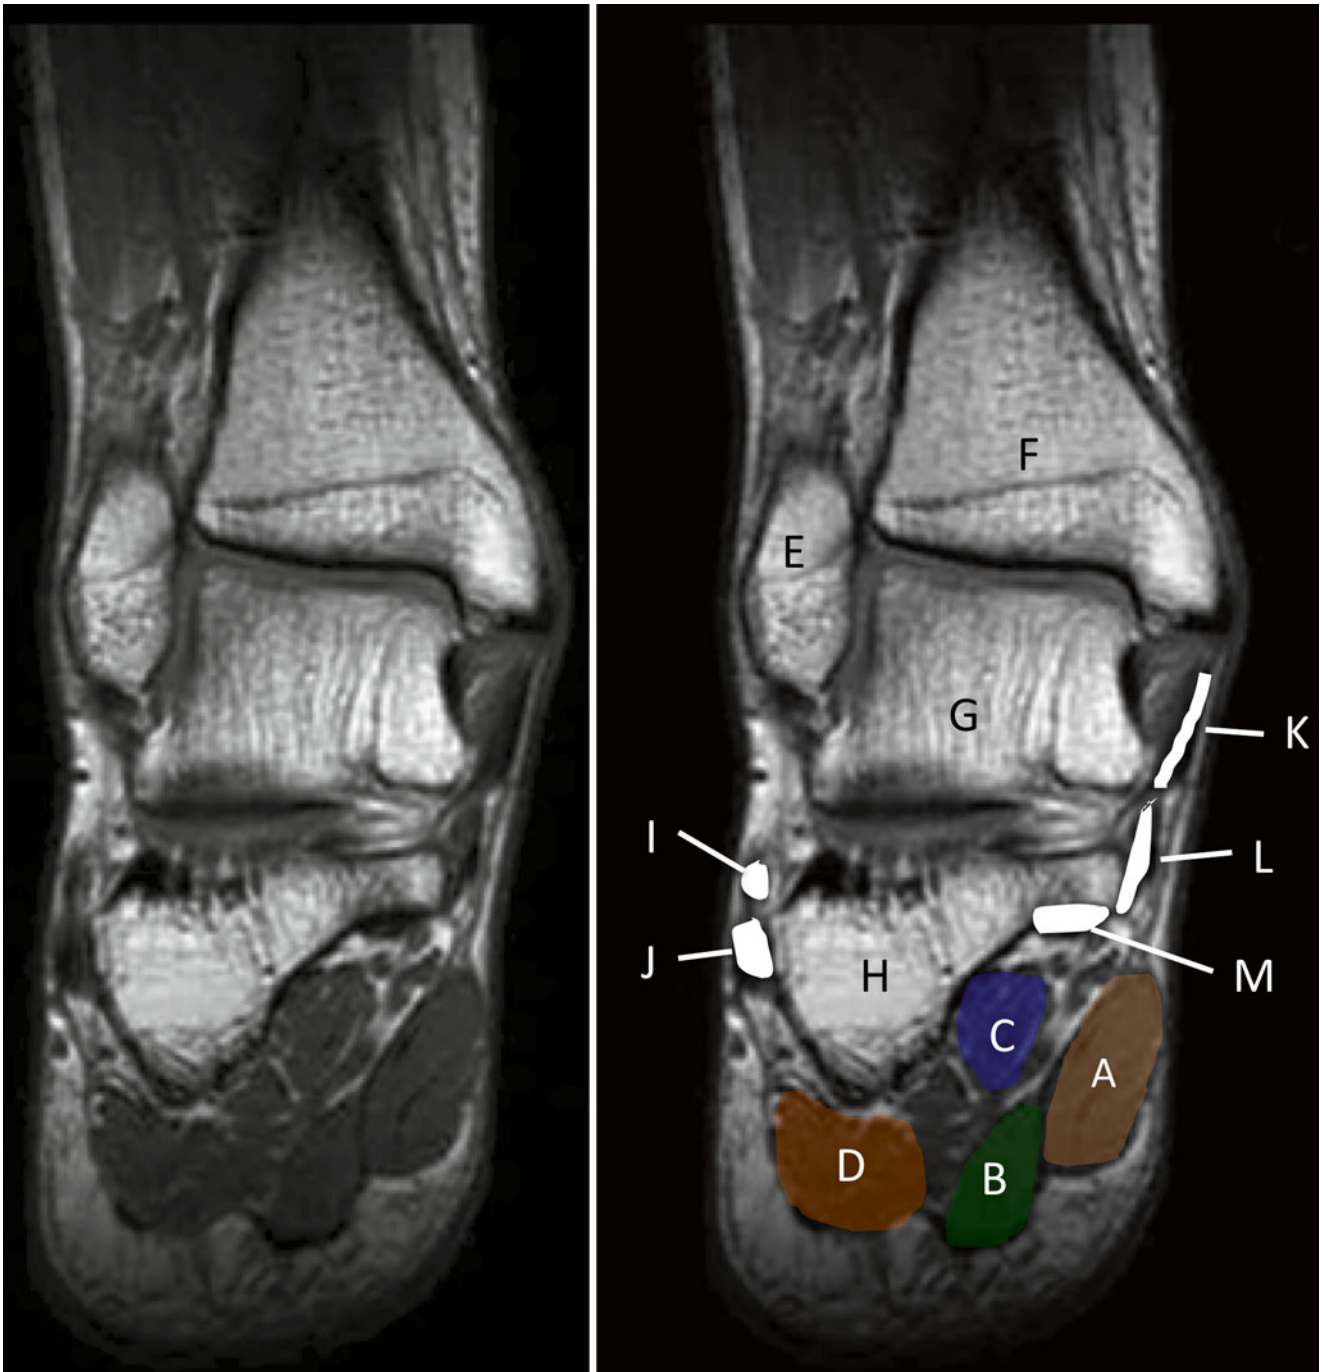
Coronal MRI images of the foot. *A* abductor hallucis, *B* flexor digitorum brevis, *C* quadratus plantae, *D* abductor digiti minimi, *E* fibula, *F* tibia, *G* talus, *H* calcaneus, *I* peroneus brevis tendon, *J*
